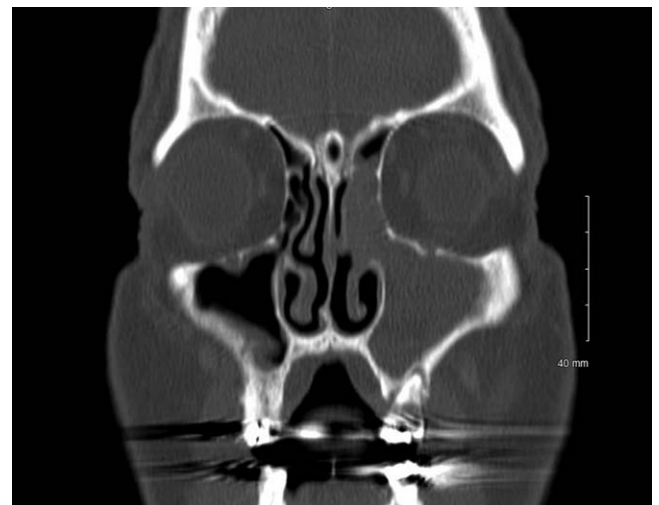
Computerized tomography (CT) in a coronal plane of a patient with odontogenic sinusitis demonstrating complete opacification of the left maxillary and anterior ethmoid sinuses with associated involvement of the ostiomeatal unit. There is a periapical radiolucency of the left maxillary first molar. Please note, this is the same patient as in Figure 2, taken a week apart.
